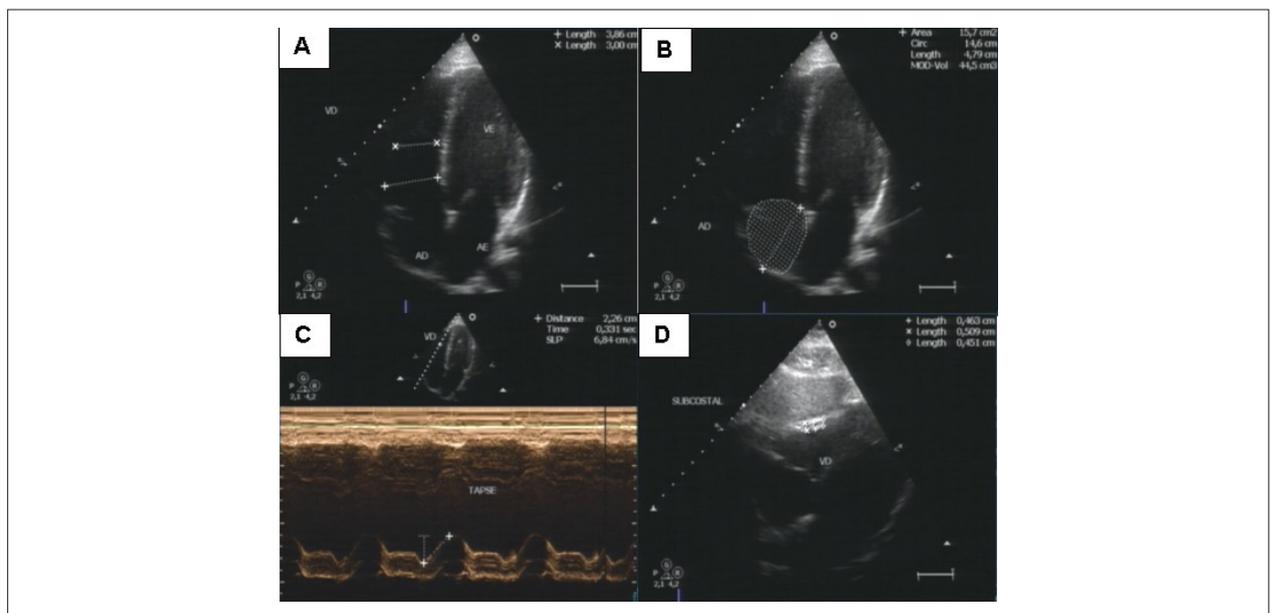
Echocardiographic image showing in (A) two-dimensional measurements of the basal and mean diameters. Four-chamber apical view of the right ventricle. (B) Apical 4-chamber view of the right atrial (RA) volume. (C) One-dimensional measurement of the tricuspid annular plane systolic excursion (TAPSE) in apical 4-chamber view. (D) Two-dimensional measurement of RV wall thickness from the subcostal view. LA: left atrium.
